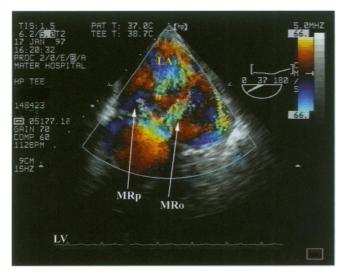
With colour Doppler applied, there is severe mitral regurgitation filling the left atrium. At mitral valve level there are two distinct regurgitant jets, one through the valve orifice (MRo) and the other through the anterior leaflet perforation (MRp).
